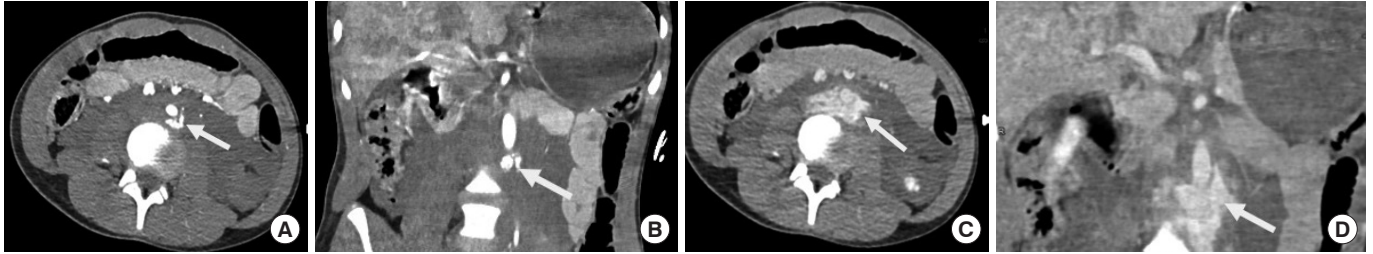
Periaortic contrast extravasation. (A) Axial and (B) coronal reformatted computed tomography images in the arterial phase show an ill-defined focus of extravasated contrast matching the blood pool (arrow) in a retroaortic location with significant retroperitoneal hemorrhaging. In (C) the corresponding axial and (D) coronal reformatted portovenous phase images, the extravasated contrast (arrow) is shown expanded and spreading around the aorta.
